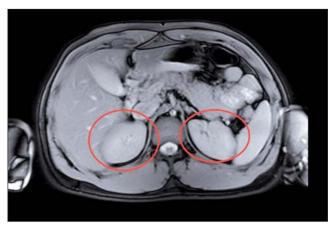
Abdominal MRI. Kidneys with normal structure.
